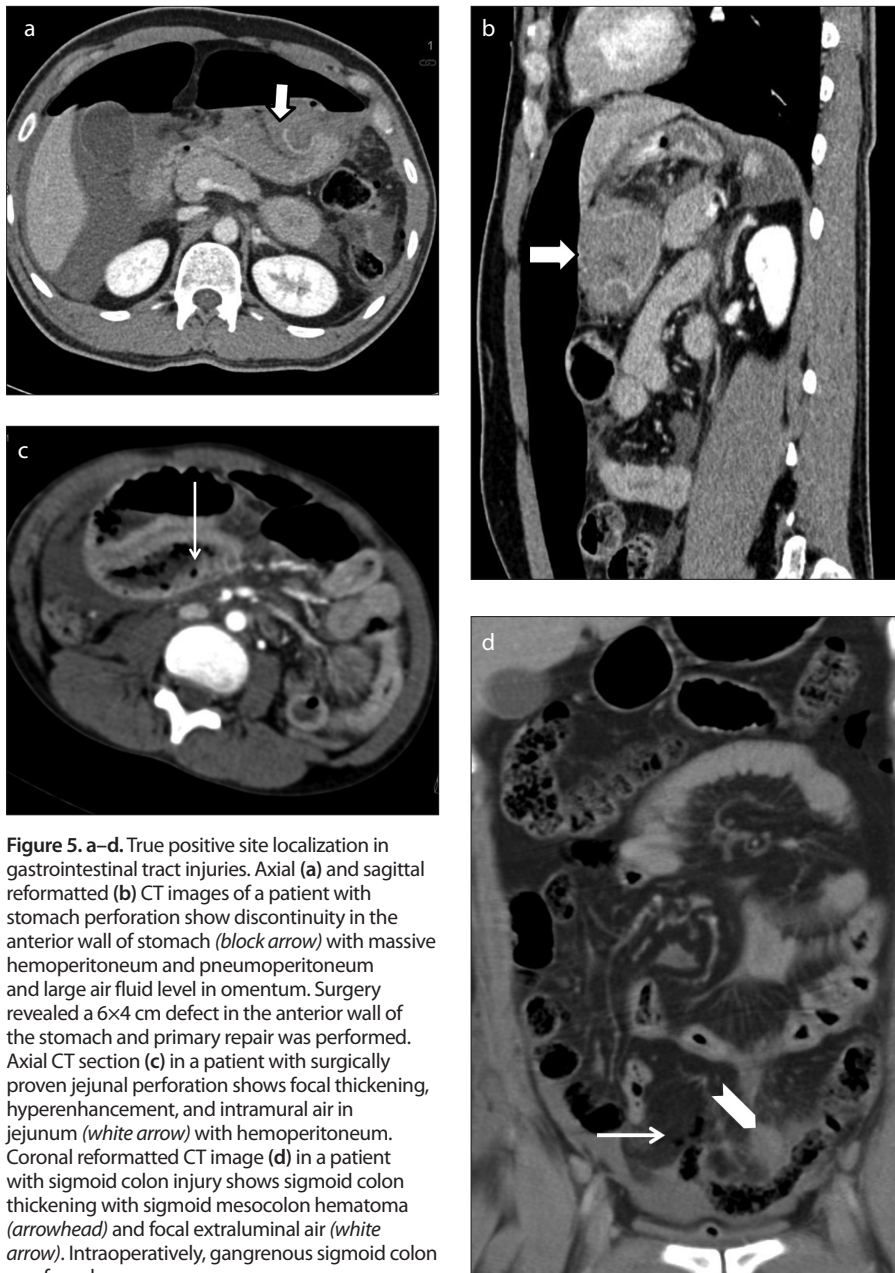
a–d. True positive site localization in gastrointestinal tract injuries. Axial (a) and sagittal reformatted (b) CT images of a patient with stomach perforation show discontinuity in the anterior wall of stomach (block arrow) with massive hemoperitoneum and pneumoperitoneum and large air fluid level in omentum. Surgery revealed a 6×4 cm defect in the anterior wall of the stomach and primary repair was performed. Axial CT section (c) in a patient with surgically proven jejunal perforation shows focal thickening, hyperenhancement, and intramural air in jejunum (white arrow) with hemoperitoneum. Coronal reformatted CT image (d) in a patient with sigmoid colon injury shows sigmoid colon thickening with sigmoid mesocolon hematoma (arrowhead) and focal extraluminal air (white arrow). Intraoperatively, gangrenous sigmoid colon was found.
